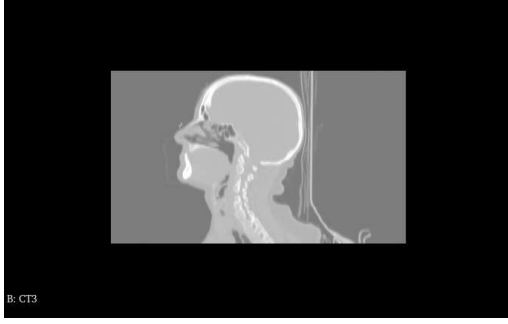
A slice of CT image from sagittal view
